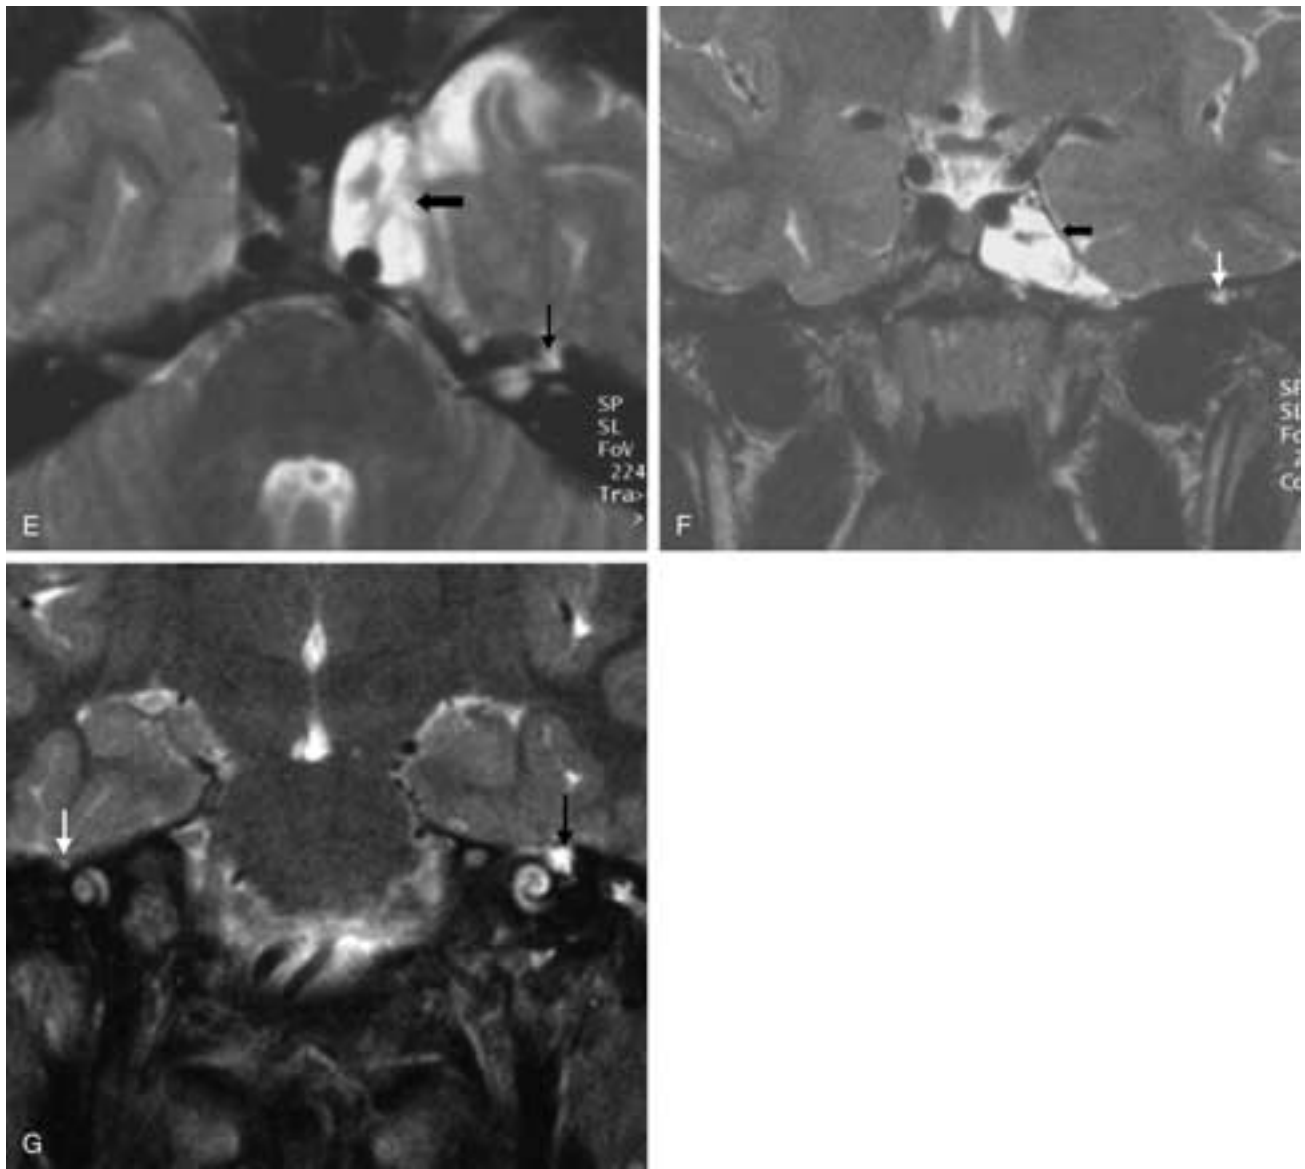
Continued.* E, Axial T2-weighted MR image with an enlarged left GG (*small black arrow*) and meningocele (*large black arrow*). F, Coronal T2-weighted MR image with an enlarged GG (*white arrow*) and a meningocele (*black arrow*). G, Coronal T2-weighted MR image posterior to F showing an enlarged left GG (*black arrow*) over the cochlea compared to the normal right GG (*white arrow*).
